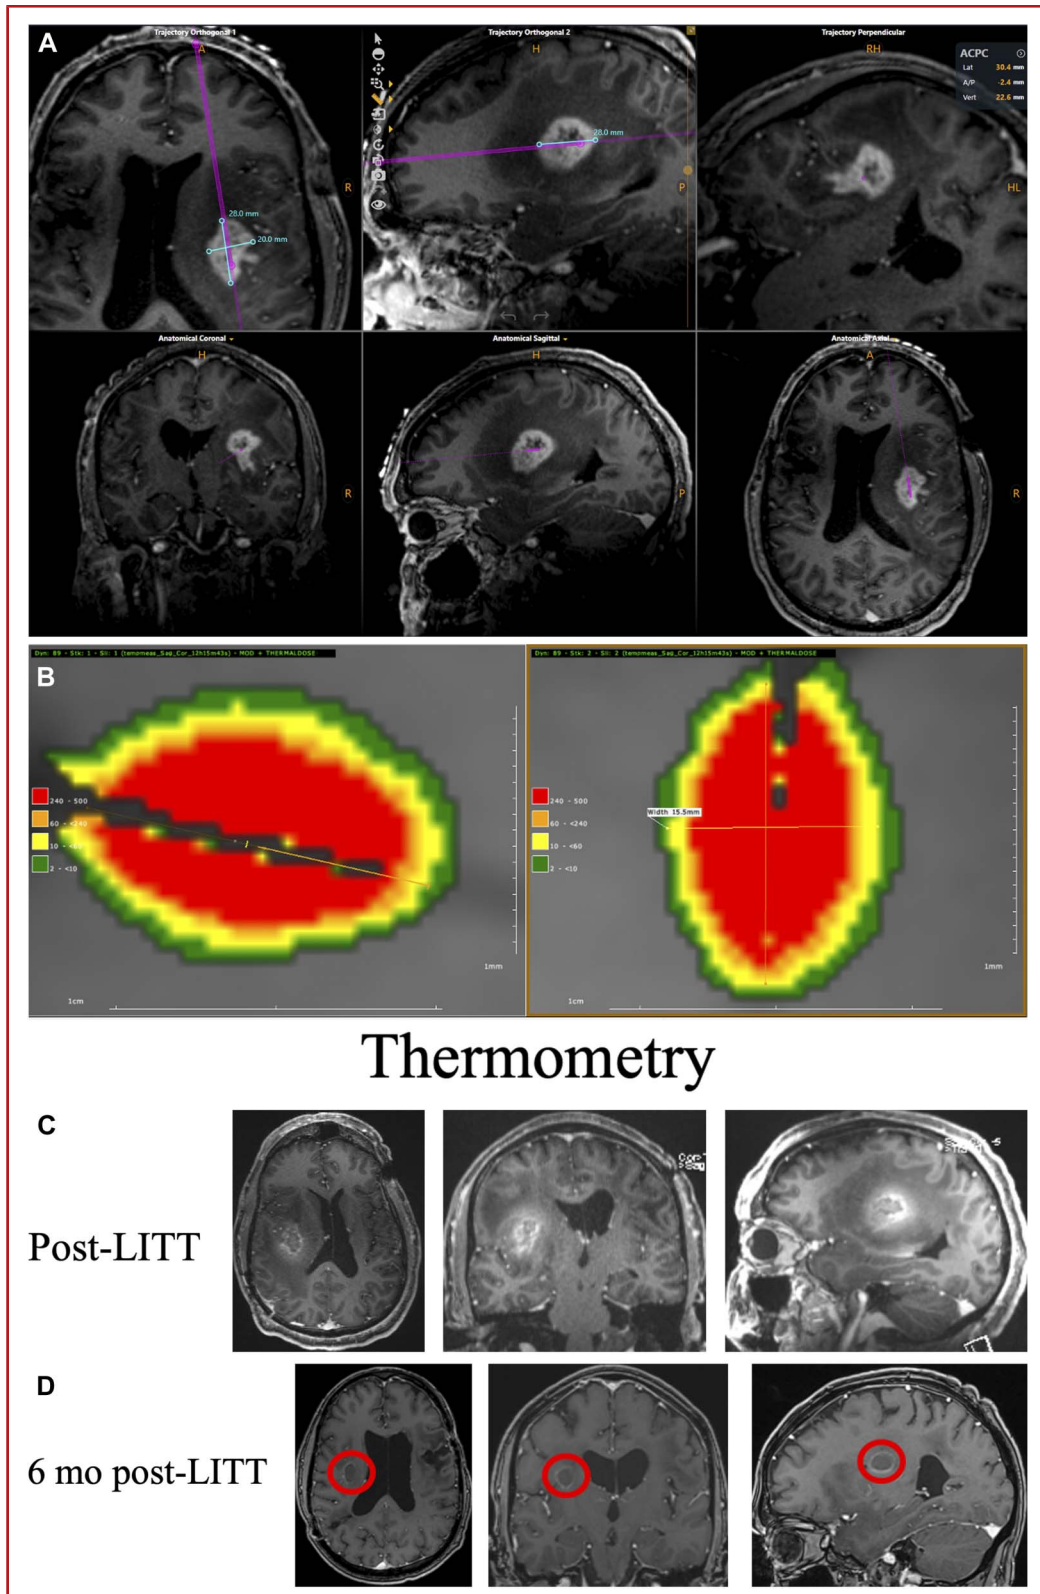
A 53-year-old man with a 3-year history of glioblastoma (IDHwt, MGMTm) who was found to have a new, progressively enlarging lesion in the right insular cortex. A, Multiplanar postcontrast MRI images (T1 with gadolinium) demonstrating stereotactic localization and right frontal-insular approach to the target lesion. From right to left, top row: axial, sagittal, sagittal images; The top row shows the planned trajectory superimposed onto the anatomic images (purple). The blue lines indicate the dimensions of the contrast enhancement. B, Intraoperative thermometry with the 15-mm diffuser probe. The ablation cavity measured 15.5 × 22.7 mm, encompassing 100% of the target lesion. See Figure 1D for the color code in thermometric assessment. C, Immediate, postoperative axial, coronal, and sagittal MRI images (T1 with gadolinium) demonstrating expected ablation cavity. D, Six months postoperative postcontrast axial, coronal, and sagittal MR images (T1 with gadolinium). LITT, laser interstitial thermal therapy.
